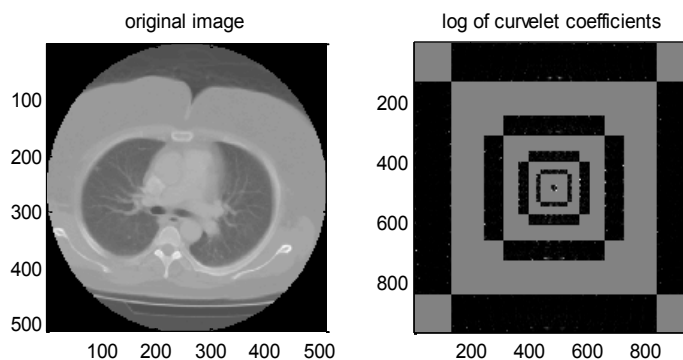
Clinical slice for the human chest from a CT scanner in spatial (left) and curvelet coefficients (right).
